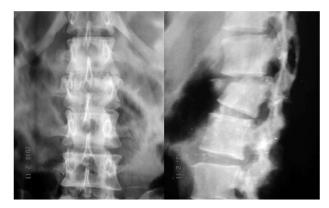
Plain radiograph gives the general anatomical feature of the vertebra but it is mandatory to have CT scan for measurement of the diameter, length and orientation of the pedicle screw.
